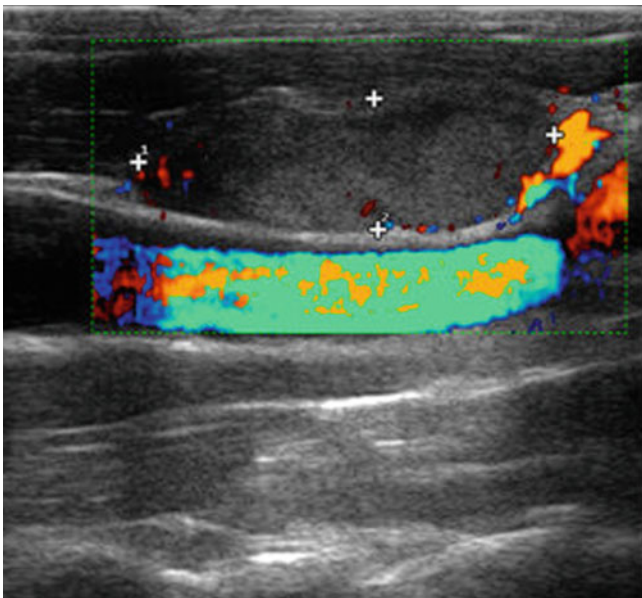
Lymph-node metastasis. Directional power Doppler image. Melanoma metastasis neighbors the sternocleidomastoid muscle and the carotid artery
